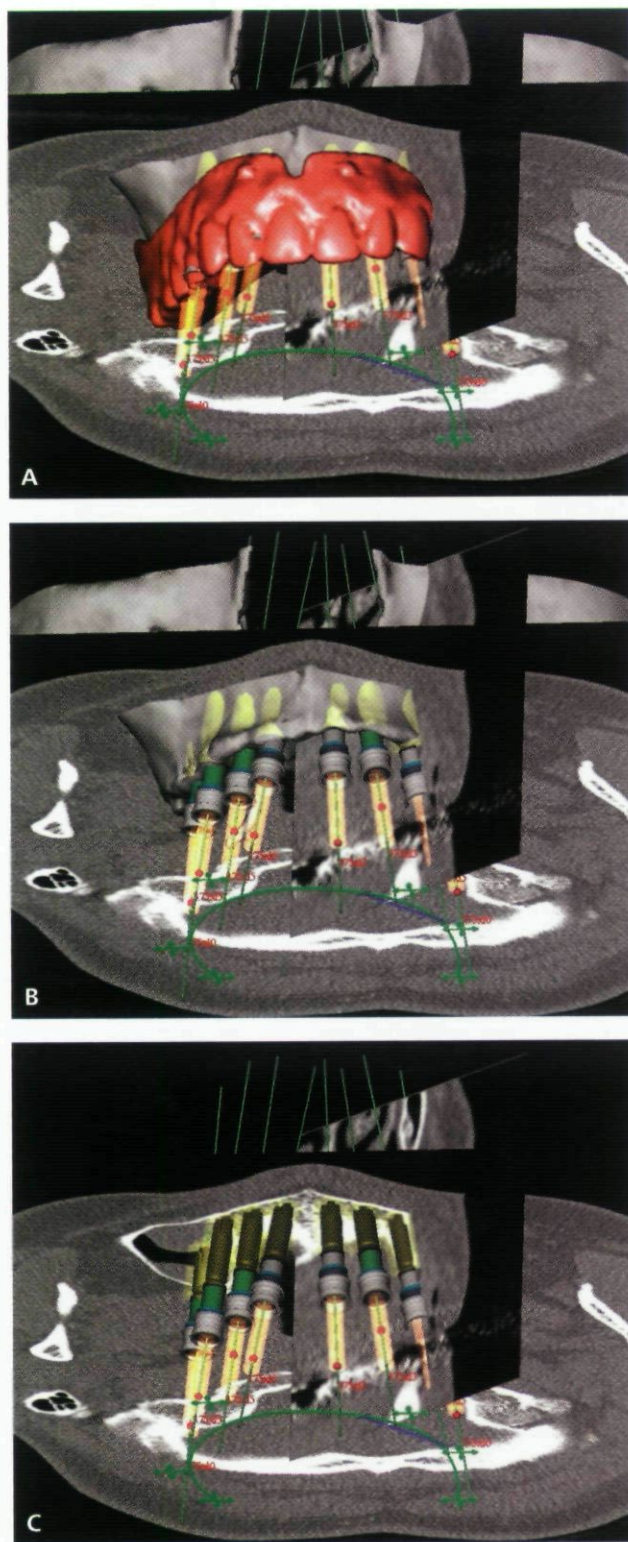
The virtual scene is filled with the objects that are important for performing implant treatment planning. At all times, the visibility of the objects, such as the computed tomographic slices, cross-sectional reslices, bone surface, or prosthesis surface, can be switched on and off. In (A), all objects are visualized. Depending on the details that are inspected, the prosthesis can be temporarily hidden (B), as well as the maxilla (C). Also, the axial slice or reslices can be displayed or hidden. In this way, only the data needed during the planning step are visualized.
